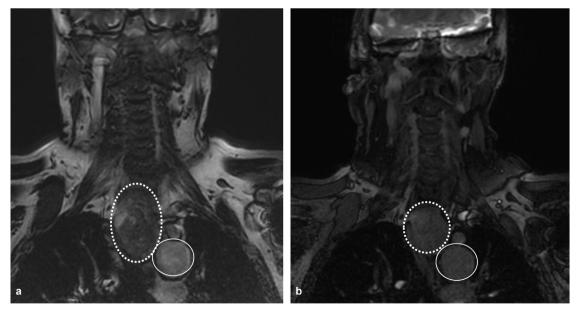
a: coronal MRI pre-embolization. Large intrathoracic left thyroid lobe (dotted line) reaching the aorta (solid line); b: coronal MRI 6 months post-embolization. Marked reduction of the intrathoracic left lobe (dotted line) and of the contact with the aorta (solid line).
